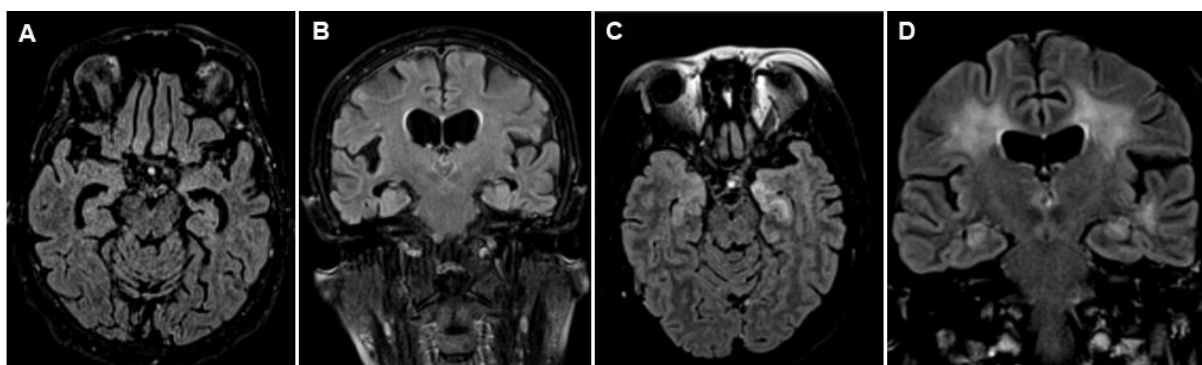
Axial and coronal FLAIR brain images from Patient 8 (Panel A, Panel B) and Patient 24 (Panel C, Panel D). Patient 8 was a 75-year-old female patient, who had anti-NMDAR autoantibody positivity detected in CSF and had hyperintensity and contrast enhancement within bilateral medial temporal lobes (Panel A-axial 3D FLAIR, Panel B-coronal T2 FLAIR). Patient 24 was a 50-year-old female patient, who had anti-LGI1 autoantibody positivity
